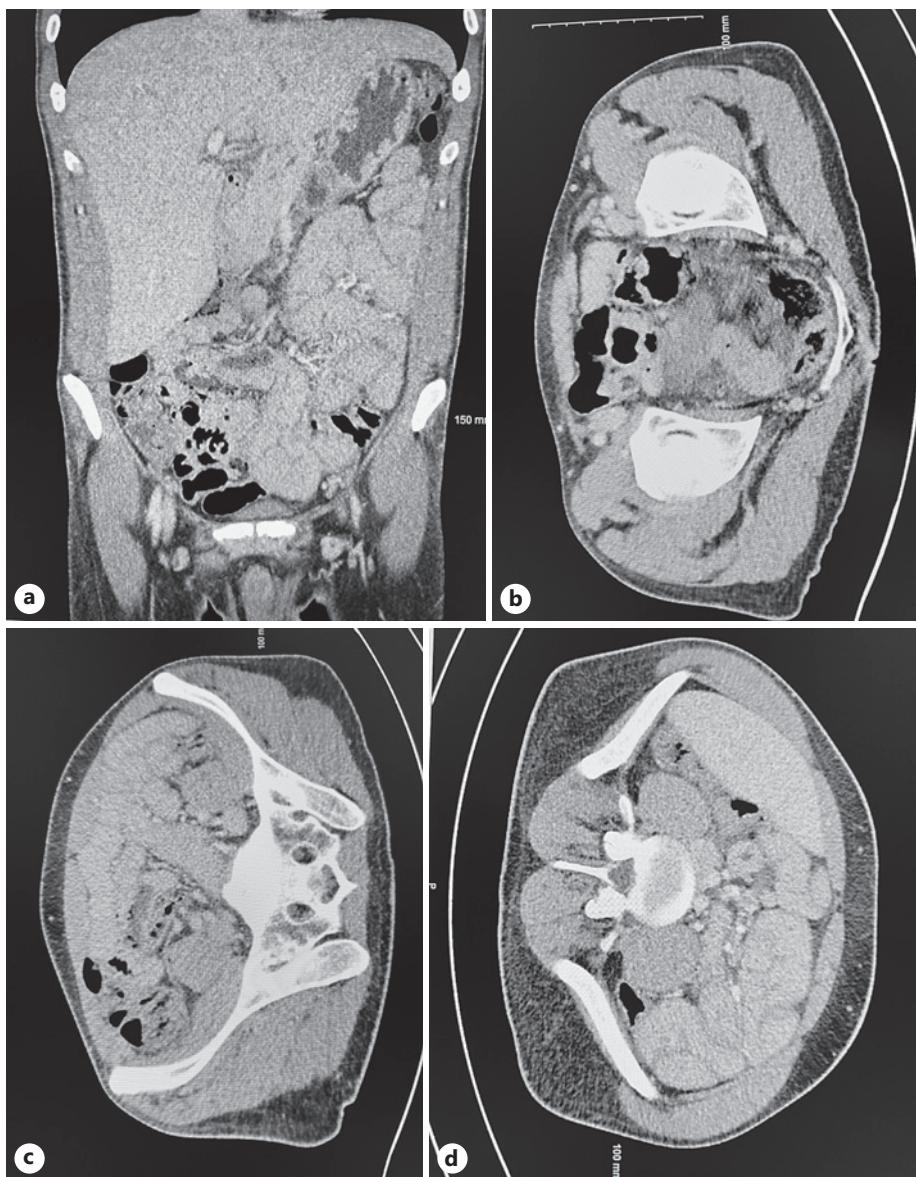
a-d Images from the CT abdomen and pelvis that was done for further work-up following positive PCR testing for *C. difficile* upon presentation, 1 week after initiating the recommended – 14-day course of fidaxomicin 200 mg p.o. BID, along with yogurt and probiotic supplementation. The images reveal several loops of thickened small bowel wall with subtle surrounding fat stranding, suggestive of enteritis.
